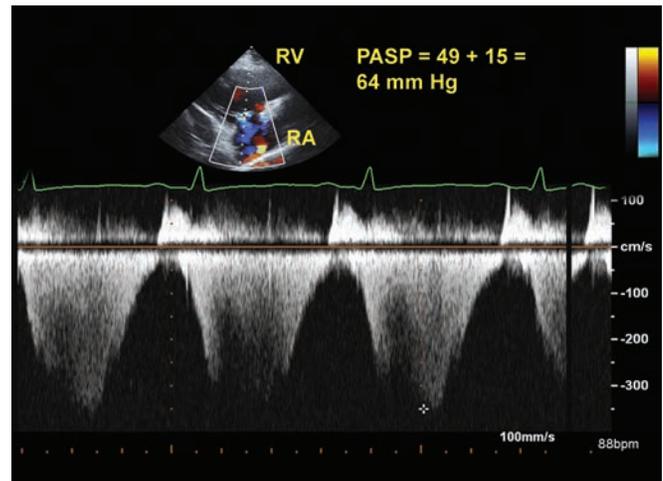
Continuous wave Doppler of tricuspid regurgitation. Shows PASP of 64 mm Hg.
